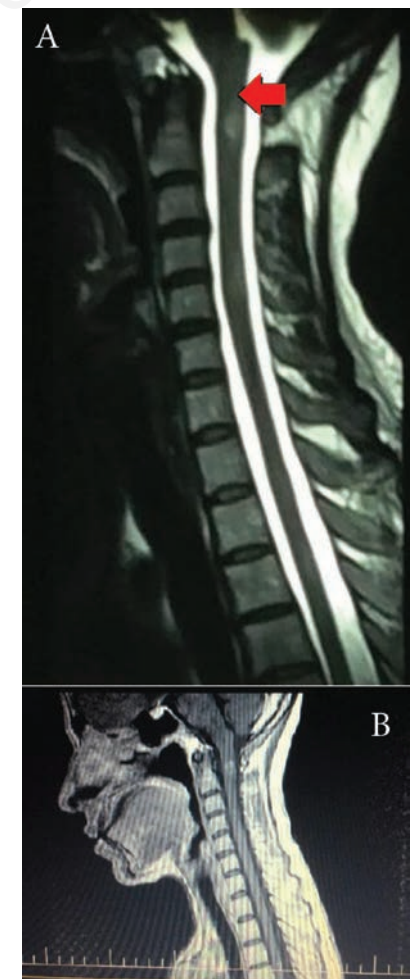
T2/W cervical magnetic resonance imaging showing a hypersignal intramedullary demyelinating plaque (A, red arrow), with enhancement on T1 with gadolinium (B).
